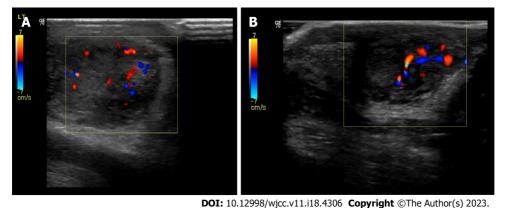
Post-operative scrotum ultrasonography. A: Post-operative ultrasonography (USG) on the 2nd post-operative day showing intact blood flow; B: Post-operative USG on the 16th post-operative day showing normal blood flow.
